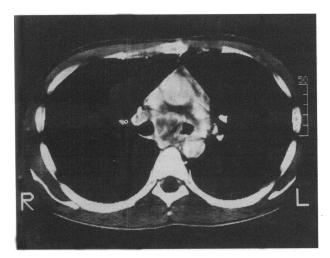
CT of chest showing enlargement of mediastinal lymph nodes in close contact to the right anterior esophageal wall.
